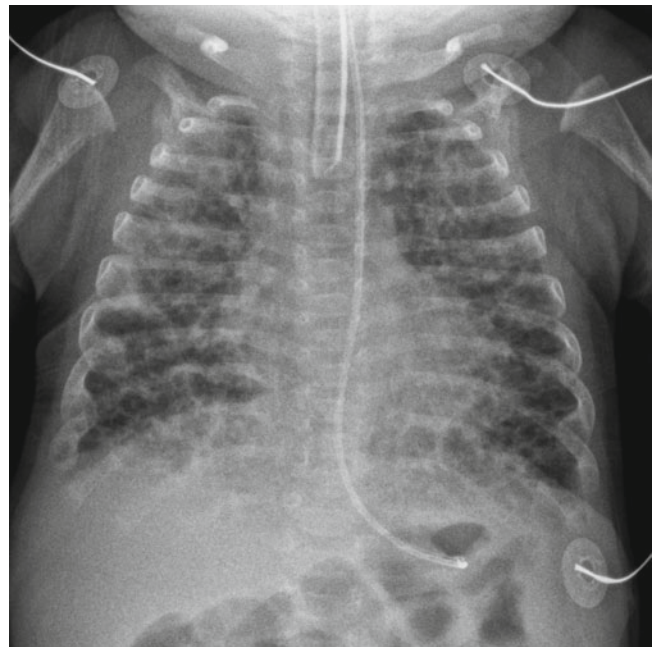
BPD in a 10-week-old infant born at a gestational age of 31 weeks. chest radiograph shows hyperinflation and numerous small round cystic areas alternating with coarse irregular opacities. The findings are more symmetrical and uniform than those seen in Fig. 11.10
